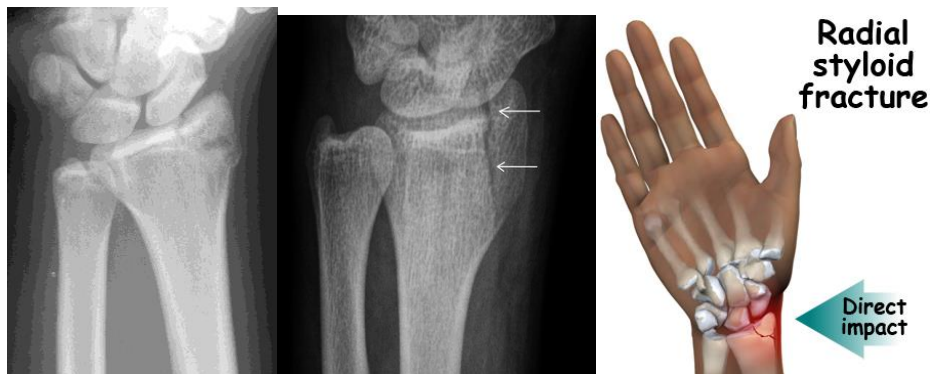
X-Ray of Radial Styloid fracture.
